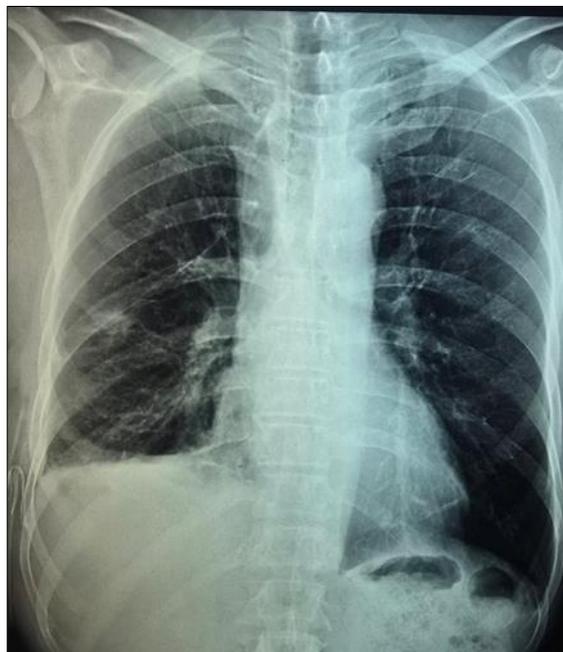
Follow-up chest X-ray showing regression of pleural opacity after treatment
